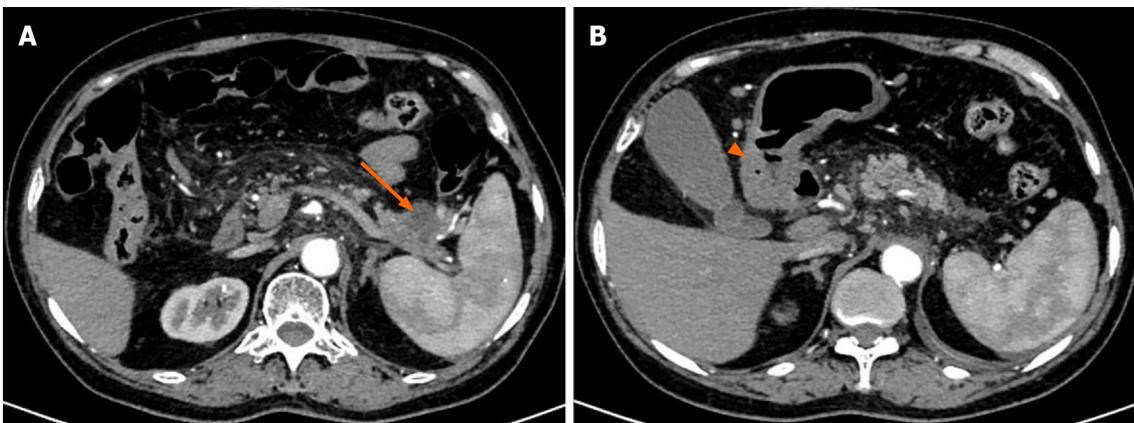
Enhanced upper abdominal computed tomography images. A: A cystic solid mass measuring 3.5 cm × 3 cm × 2 cm in the cauda pancreas (orange arrow) surrounding the splenic vessels; B: Thickening of the antral wall and slight obstruction of the pylorus (orange arrowhead).
